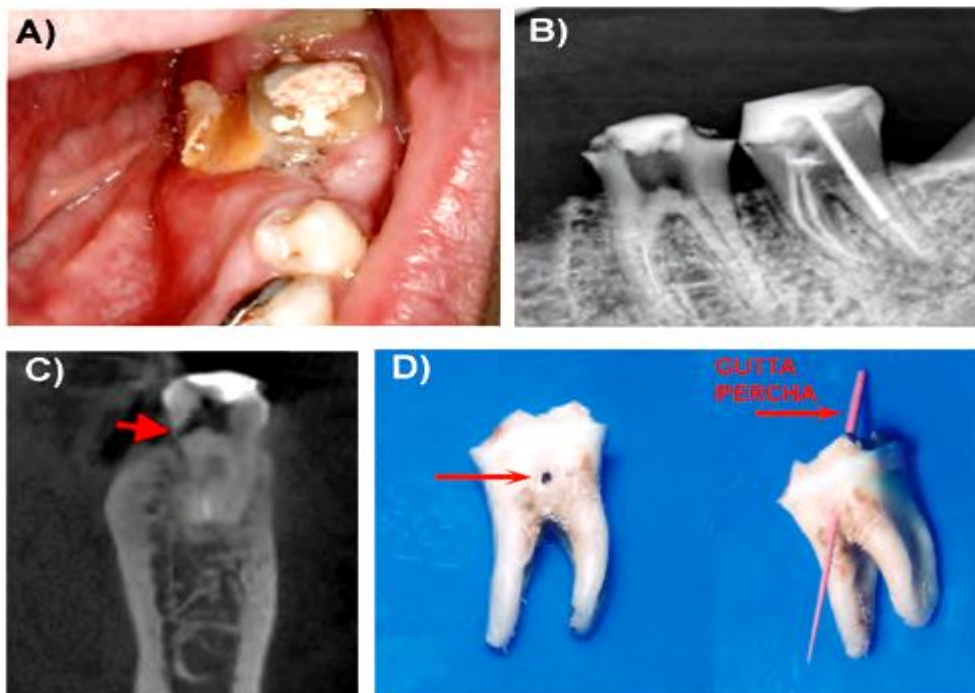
(a) Clinical picture demonstrating soft-tissue sloughing of lingual gingiva after application of sodium hypochlorite during endodontic treatment of 36 tooth. (b) Midtreatment periapical radiograph erroneously demonstrating unperforated root of 36 tooth. (c) CBCT cross-section showing perforation of the lingual surface of 36 tooth at the cervical area (arrow). (d) After extraction of 36, the perforation is clearly seen (arrows). A gutta percha cone has been inserted in the perforation through the coronal surface of the tooth..
